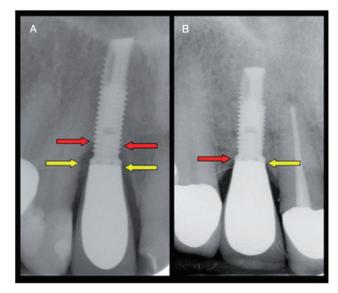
Periapical radiograph of an implant in function for 52 (A) and 54 (B) months, respectively, representing the worst and the best radiographical image of bone loss. The yellow arrow indicates the reference point from where bone level was determined. Bone level indicated by the red arrow.
